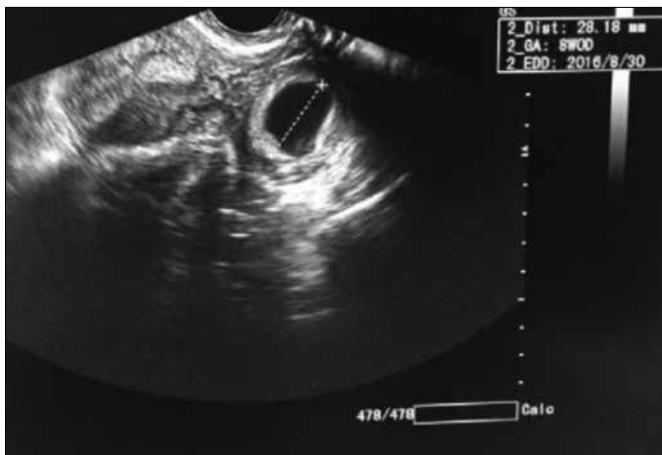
Ultrasound image of rudimentary horn pregnancy
